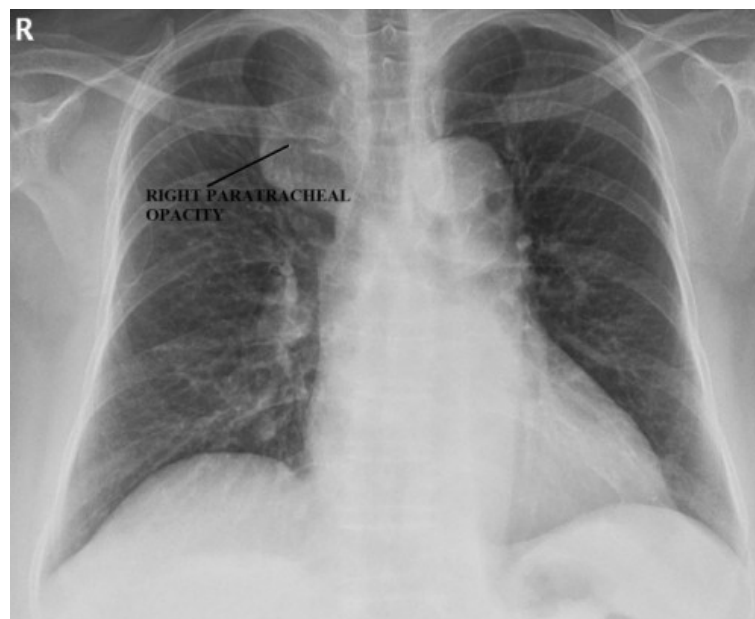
Chest X-ray PA view showing right paratracheal opacity
